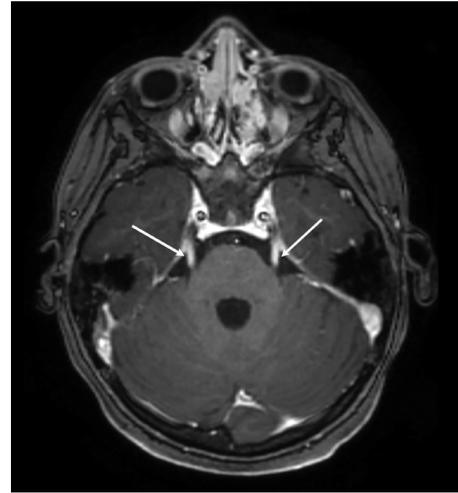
A 4-year-old female with COVID-19, suspected Guillain-Barré: Axial, post-contrast, T1-weighted image at the level of the cisternal trigeminal nerve as it enters the pons shows bilateral cranial nerve V enhancement (white arrows), confirms clinical suspicion of Guillain-Barré syndrome.
